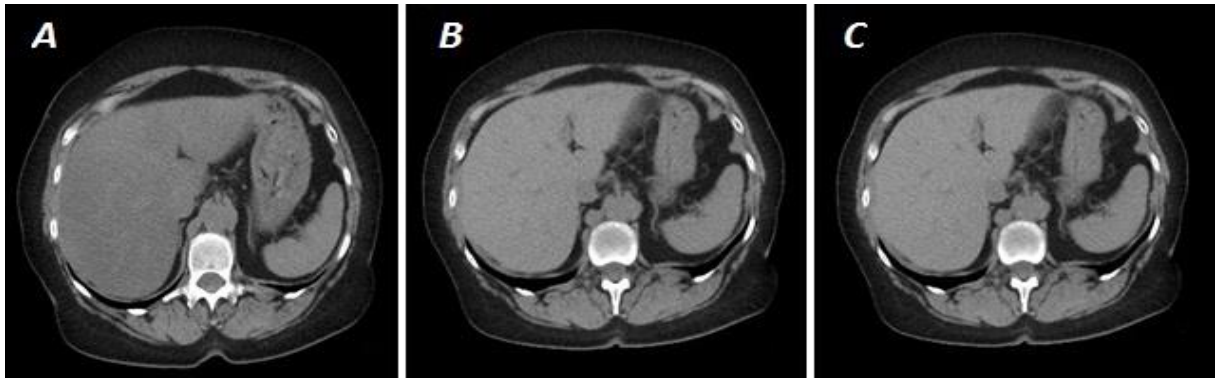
Typical plain CT images in new-onset type 2 diabetic patients before and 4 months after the start of metformin therapy and in control subjects. The density of the liver was diffusely decreased in new-onset type 2 diabetic patients (A) as compared with control (C). Metformin therapy increased liver density in the diabetic patients (B) like the density in the control liver (C).
